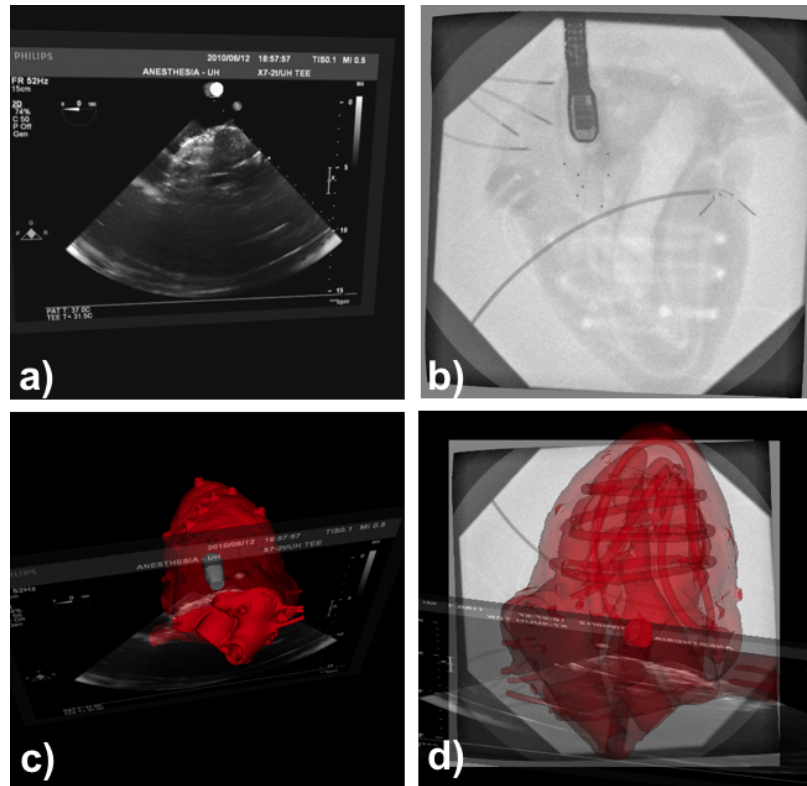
a) TEE Image b) Fluoroscopy Image c) Manual registration of CT to TEE image. d) Registration of TEE and corresponding CT.
